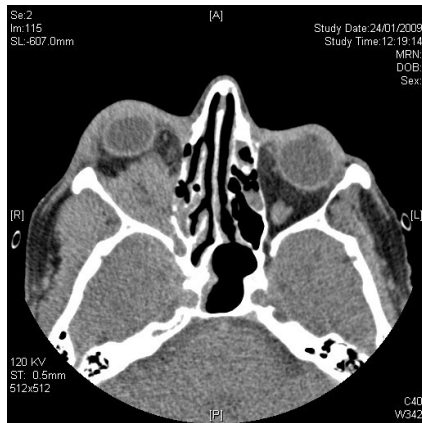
Axial CT scan showing a right postero-inferior intraorbital soft tissue mass, involving the lateral and inferior recti muscles, which is stretching the optic nerve and extending into the maxillary sinus, pterygopalatine fossa and infratemporal fossa
